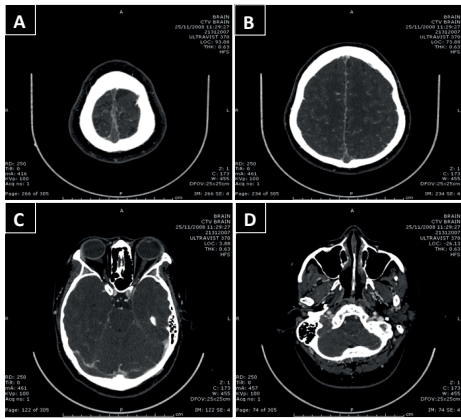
A 27 year-old female presented with symptoms of severe headache, nausea and vomiting for 3 days. She had been taking oral contraceptive pills for 3 months. Physical examination on admission revealed good consciousness with GCS of 15. The physical examination on admission revealed papilledema. An emergency CT brain was performed with the result showing long segment of occlusion of SSS (A-B), right transverse sinus (C) down to right internal jugular vein (D). The diagnosis of CVST SSS, right transverse sinus, right sigmoid sinus and right internal jugular vein was confirmed. Pretreatment mRS score = 3, then after anticoagulant therapy, posttreatment mRS score = 1 good outcome.
